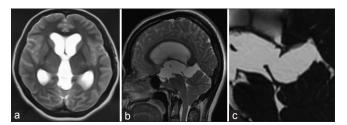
(a) PreoperariveT2-weighted on the axial section revealed a marked dilatation of the lateral and third ventricles. (b) Sagittal section of MRI showed that the cyst was iso-intense to the CSF, indicating that the arachnoid cyst was located at the quadrigeminal cistern and extended into the supracerebellar cistern and to the floor of the third ventricle, protruding downwards; it also revealed that the fourth ventricle was normal. (c) HeavilyT2-weighted MRI image clearly revealed the discontinuity between the anterior part of the cyst wall and the third ventricle.
